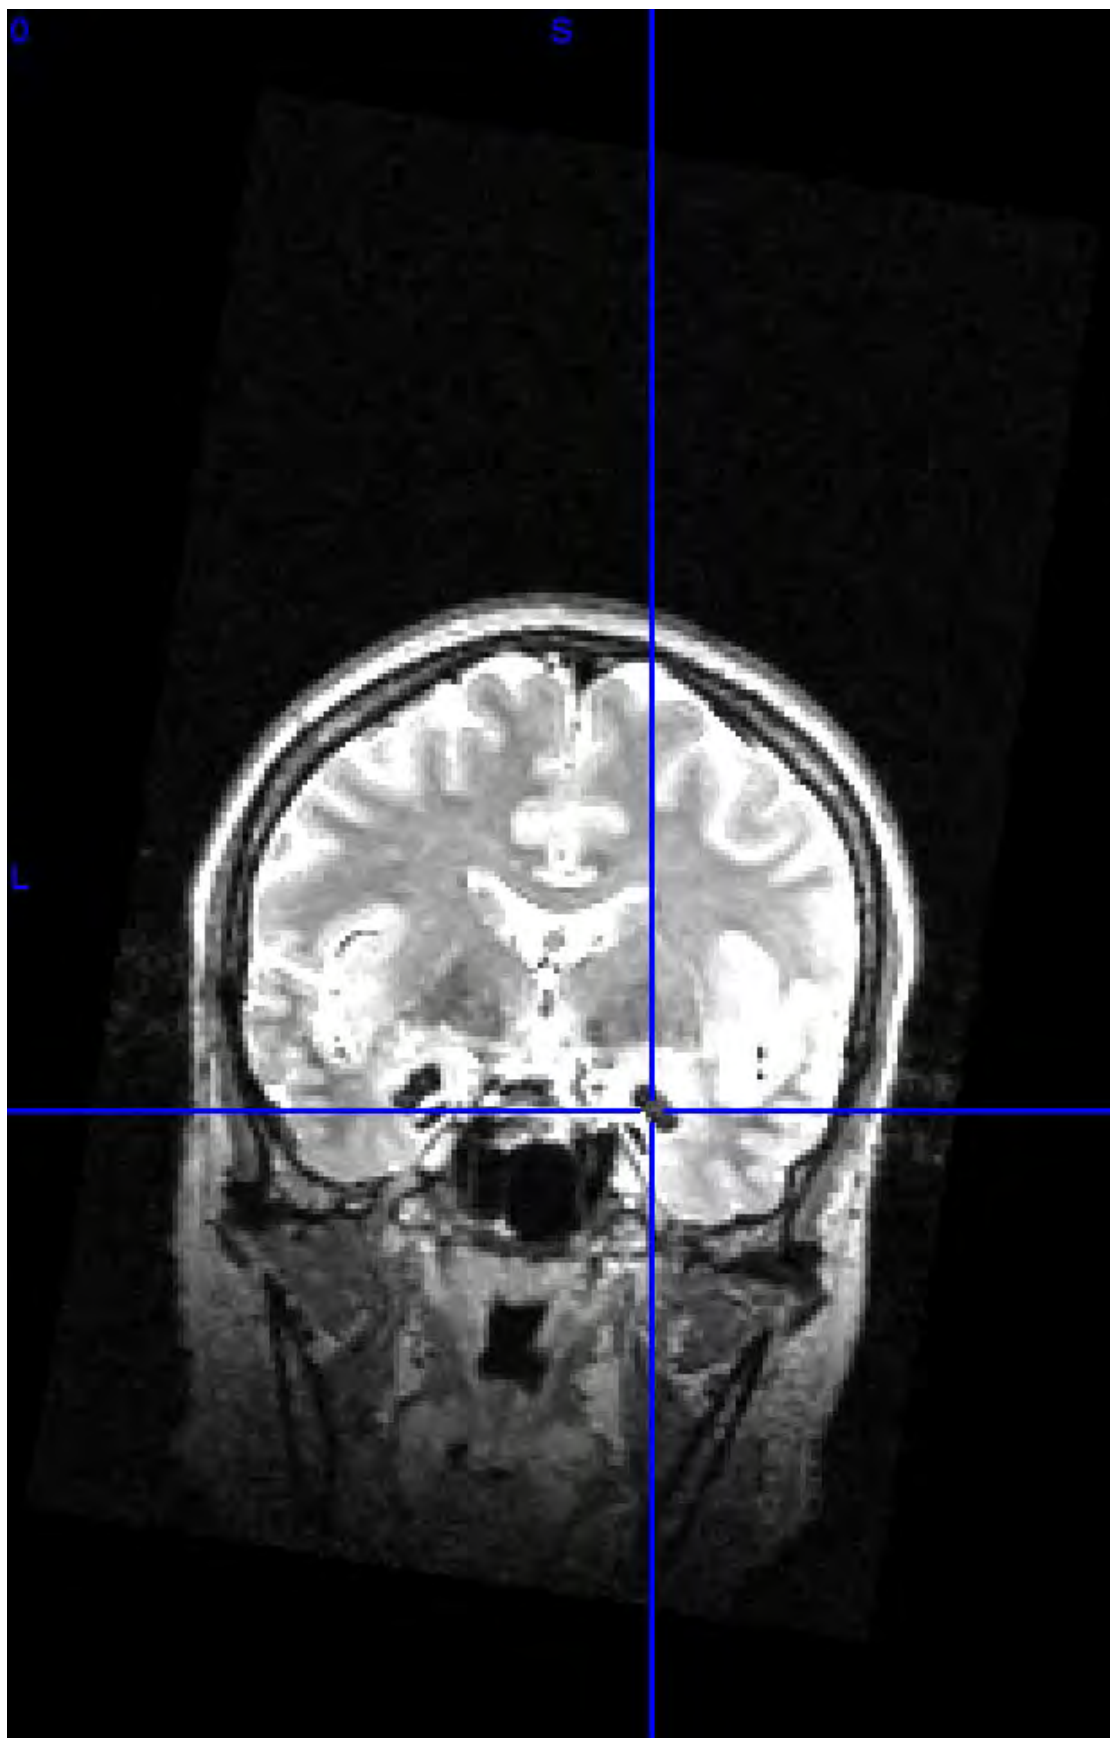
MRI scan for UWD patient no. 2.
